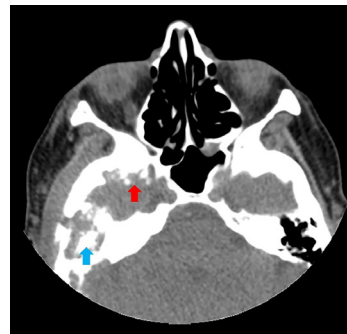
Axial pre-treatment paranasal sinus CT scan without contrast at sphenoid sinus level. The red arrow shows an osteolytic metastatic lesion in the right greater wing of the sphenoid sinus, and the blue arrow shows an osteolytic metastatic lesion in the right temporal bone.
